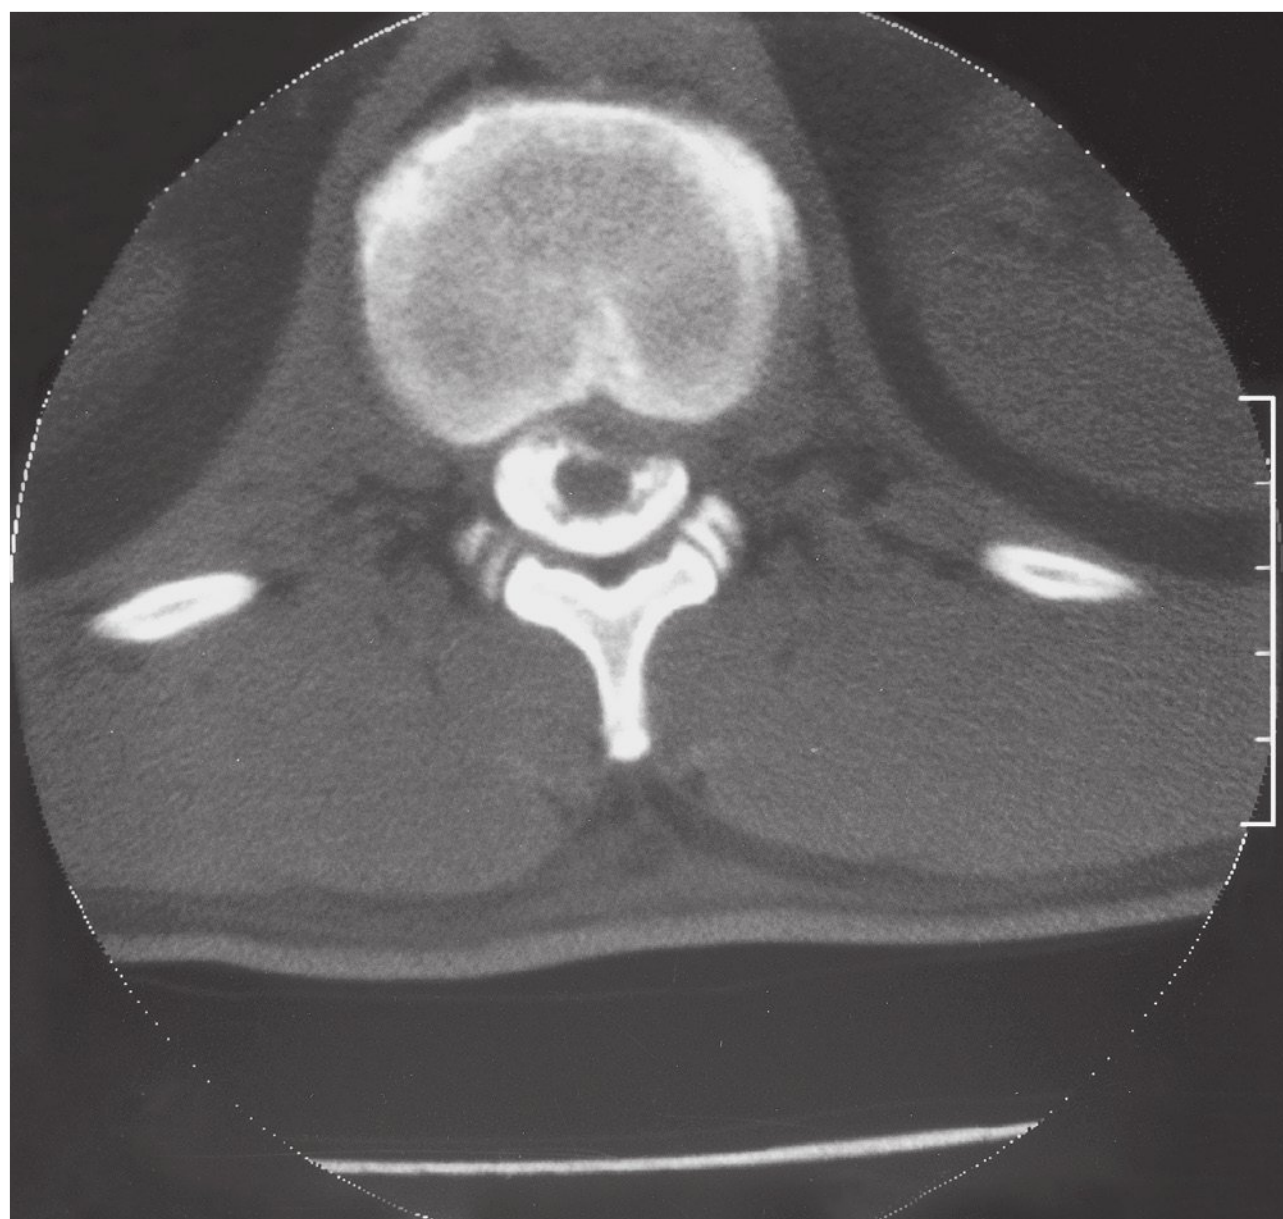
Computed tomographic myelography of the disk herniation in Fig. 15.1, demonstrating effacement of the spinal cord.
